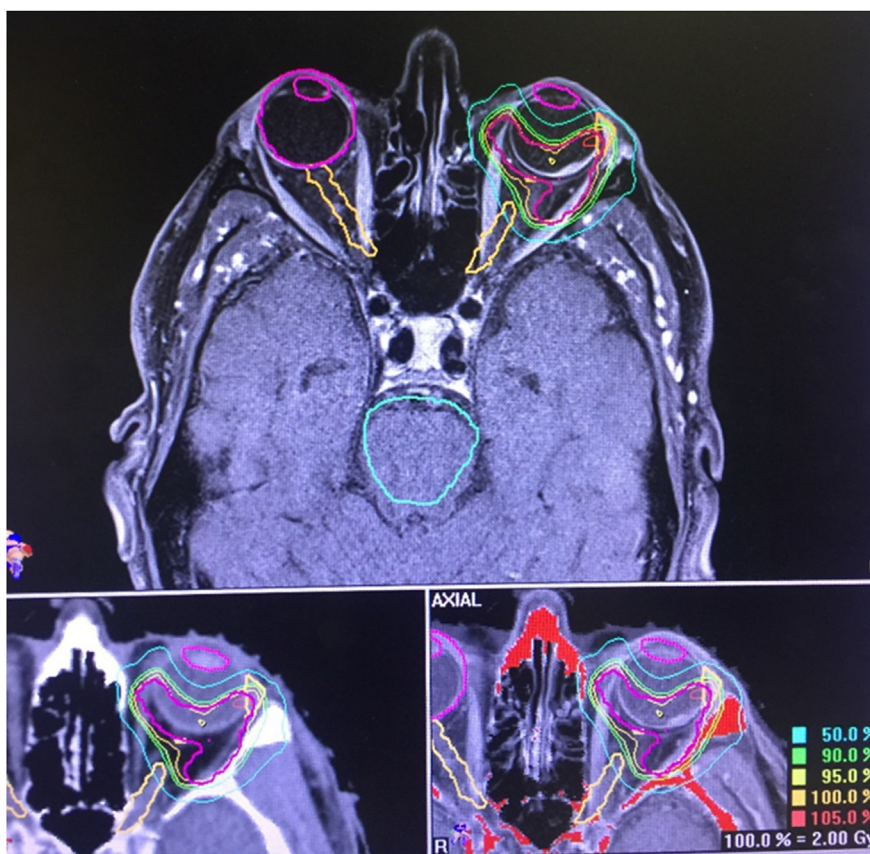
Representative slice of IMRT plan shows conformal isodose distribution with sparing of nearby normal tissues (lens, lacrimal gland, brain, and contralateral orbit). The choroidal lesion is well-visualized with MRI fusion.
